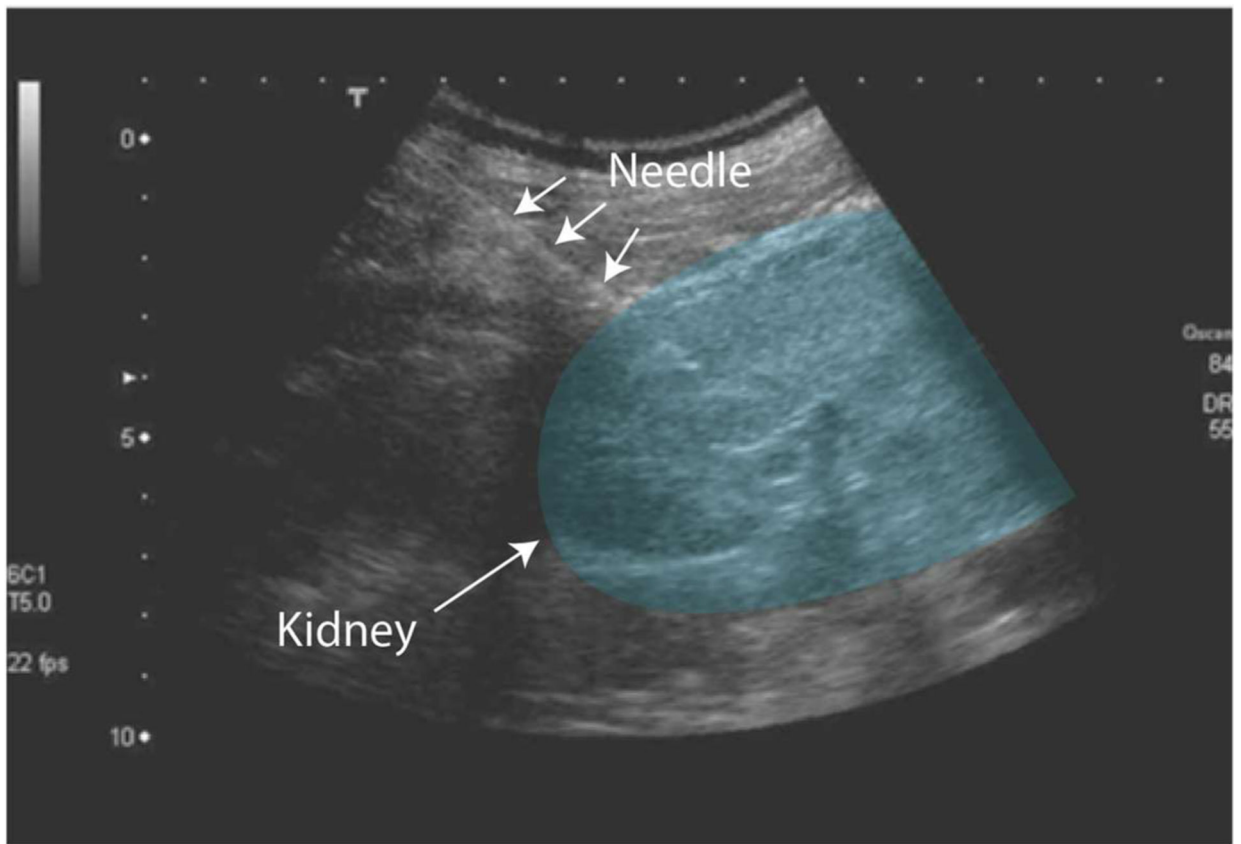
Ultrasound of kidney during needle biopsy. The needle inserted into the lower pole of the kidney is indicated with arrows.
